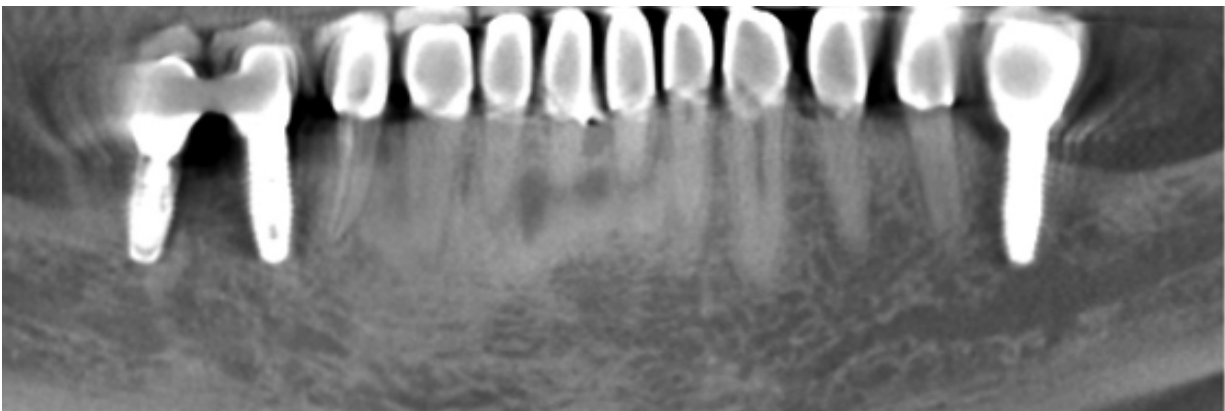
CBCT scan used after implant placement shows lower resolution of bone around dental implant due to interaction with titanium implant
